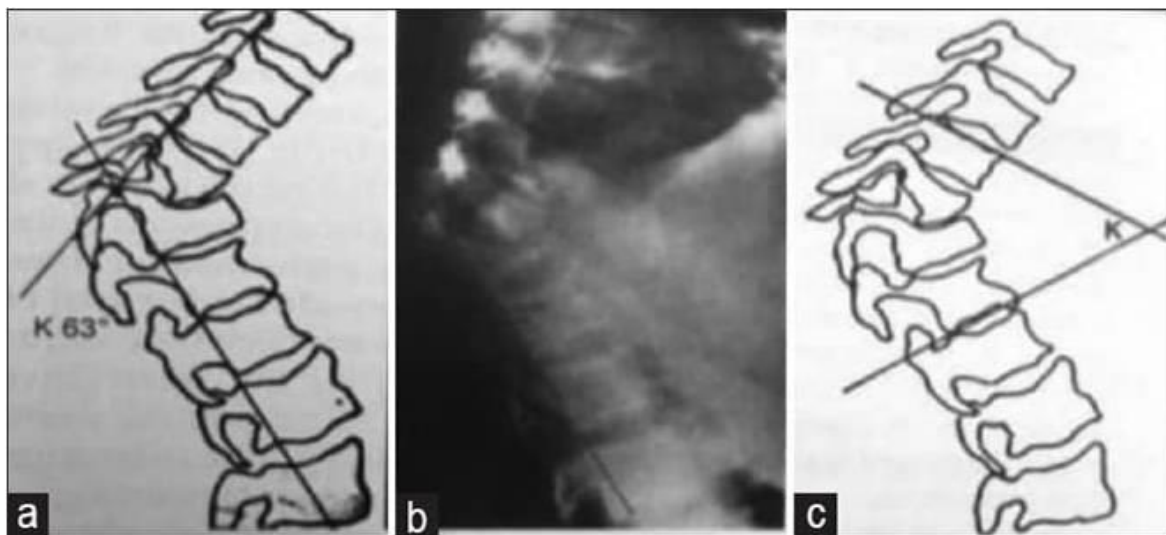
Measurements of kyphotic angle: (a) Dickson method, a line is drawn along the posterior margin of the bodies of the healthy vertebral above and below the site of disease, angle K is the angle of kyphosis; (a) lateral spine radiography used for measuring the kyphotic angle and (c) Konstam and Blesovsky (Medical Research Council) method, is by determining the angle between the upper - end - plate of the normal vertebral proxima to the affected vertebrae and the lower – end - plate of the normal vertebral distal to the affected vertebrae. Angle K increases with increase in the angle of kyphosis. Derived from the internet, www.slideshare.net [1]
